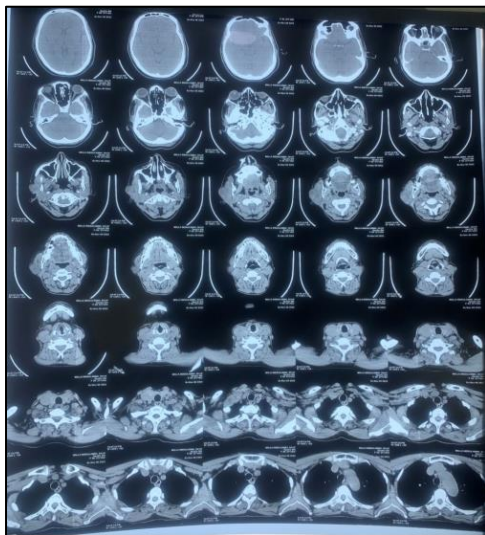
CT scan showing a well-defined heterogeneous density lesion, predominantly cystic with solid components, involving the parotid gland.
